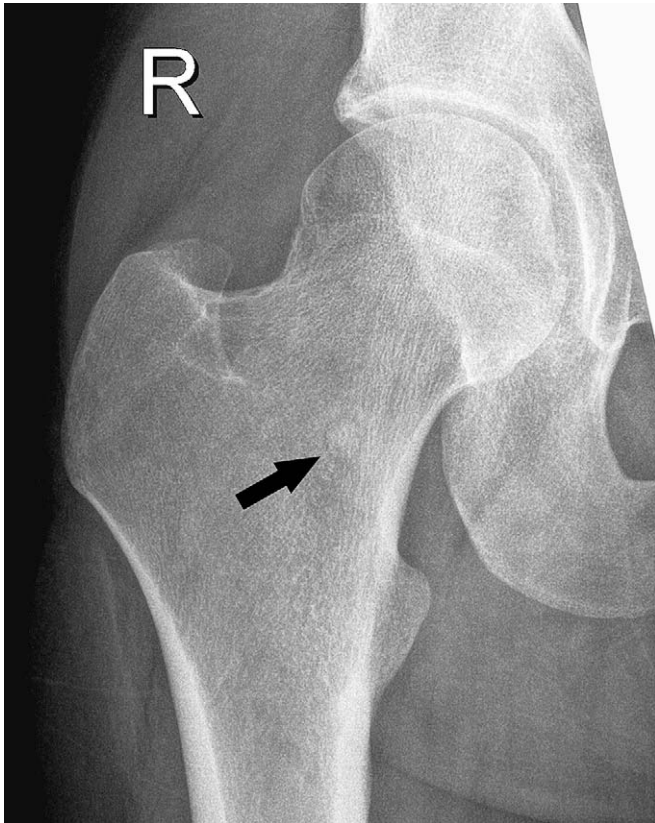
Anteroposterior radiograph of the right hip shows a 6-mm, sclerotic focus surrounded by a thin, uniform, lucent rim projecting over the femoral neck. No gross peripheral sclerosis or periosteal reaction is shown.
